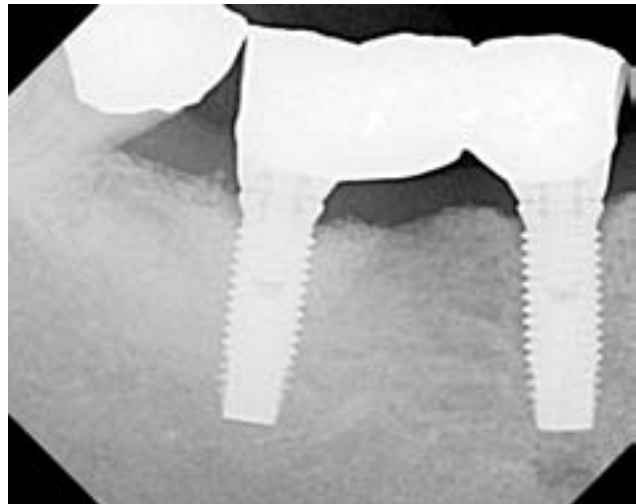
Radiographic presentation of the final restoration.
